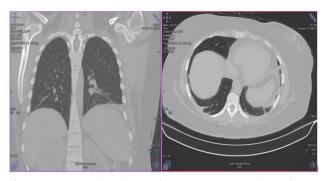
Coronal and axonal CT sections: Band ventilatory disorders such as atelectasis and bilateral basal condensations (Reprinted with permission of patient)
